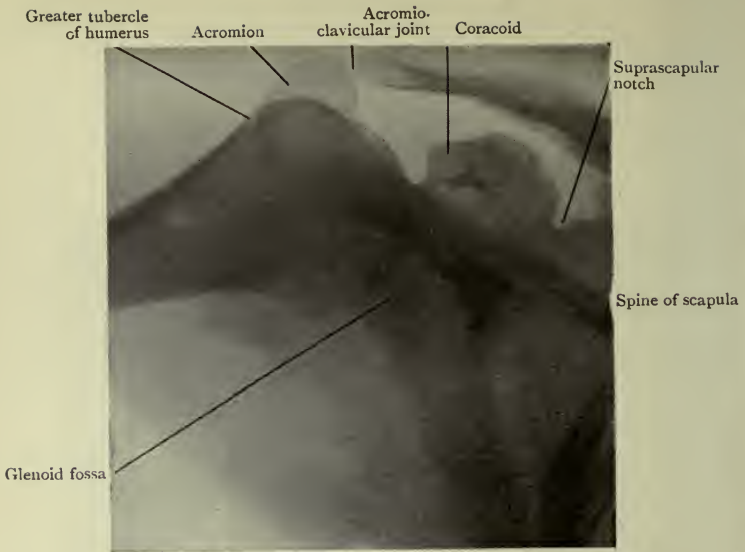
Radiograph of Shoulder Region with Arm fully abducted.
